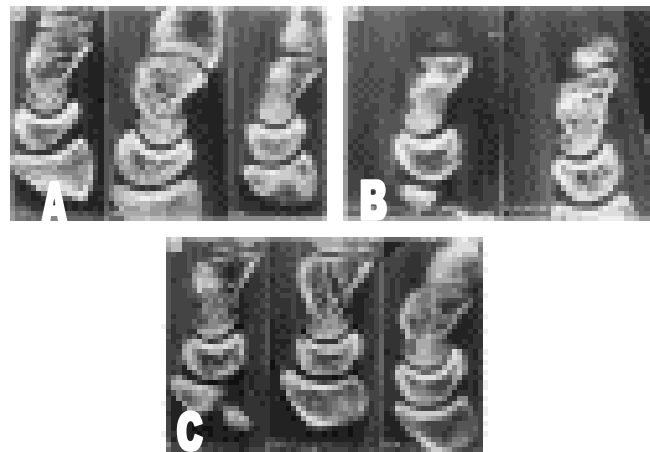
Sagittal images obtained on CT showing various shape patterns affecting the lunate. (A) Type 'D' lunates with thinner dorsal segment. (B) Type 'V' with thinner volar segment. (C) Type 'N' with equal dorsal and volar segment.
